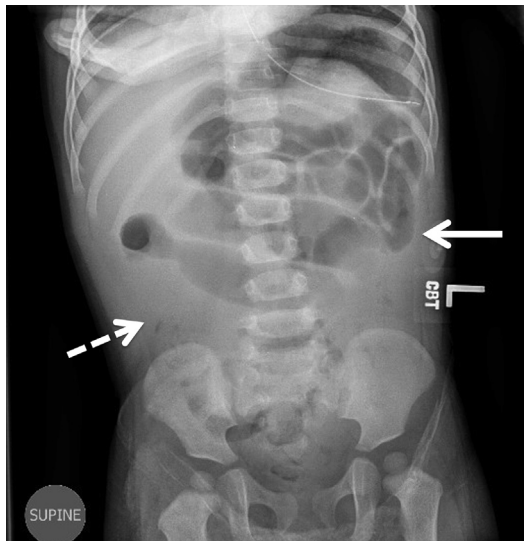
Abdominal plain film shows concern for small bowel obstruction with multiple air-filled loops of dilated small bowel (*solid arrow*) with the absence of gas in the right lower quadrant (*dashed arrow*).
